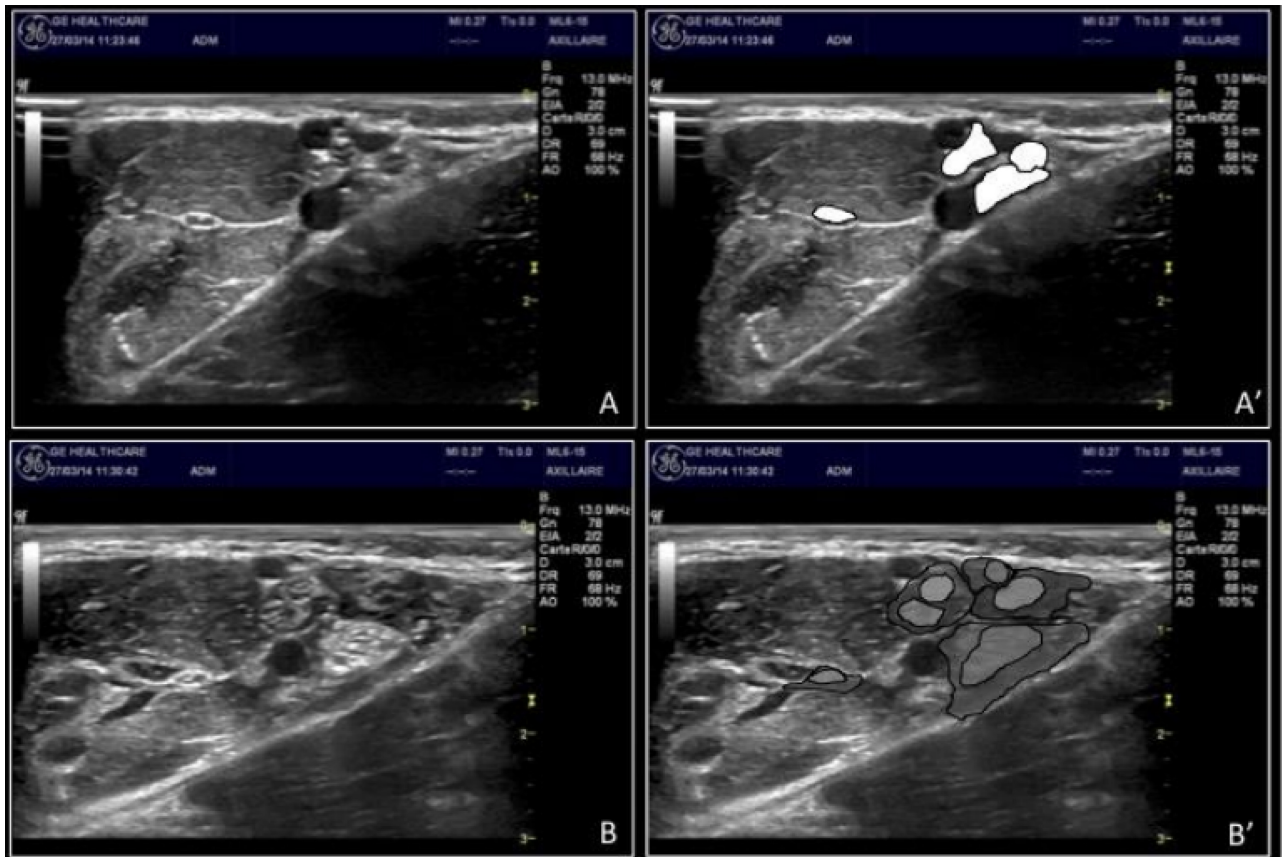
Ultrasound images of the axillary fossa before (A and A') and after (B and B') TISPE (nerves and pools of local anaesthetic superimposed on sections A' and B') [11].
